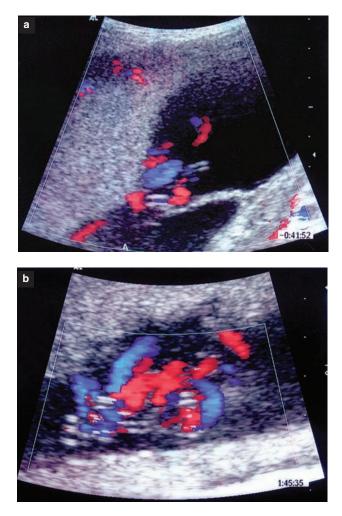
(a) Transabdominal color ultrasound in a dichorionic–diamniotic triplet pregnancy at 14 weeks. Note the simple loop of cord entanglement close to the placental insertion of the two cords of the monoamniotic triplets and Doppler velocimetry of the same segment, confirming cord entanglement by two different heart rates of the involved umbilical arteries. (b) Transabdominal color ultrasound of the same case at 18 weeks. Note the increased braiding with overlapping vessels of the two crossing cords, suggestive of 'branching'
